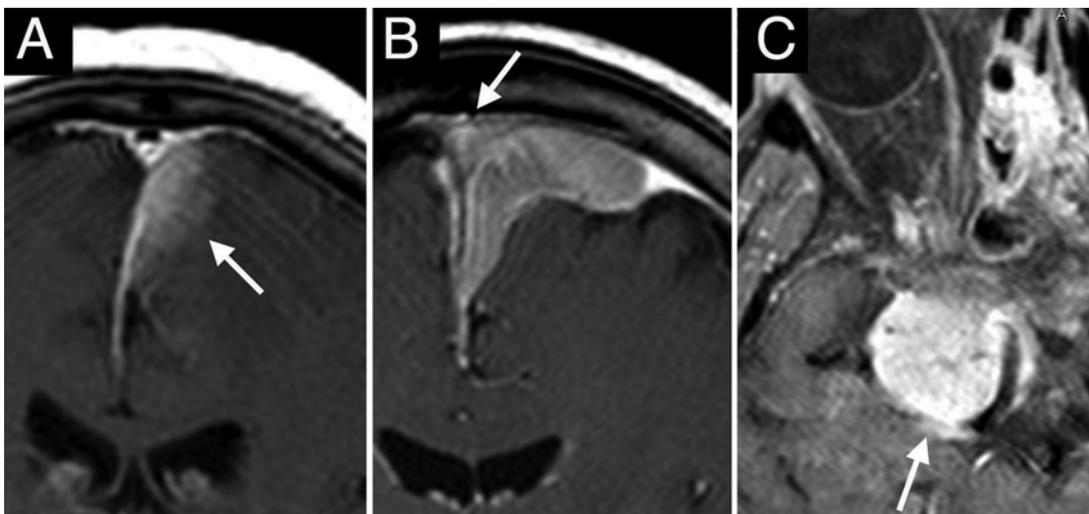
Magnetic resonance images showing examples of unclear tumor borders. Unclear borders (arrows) between the tumor and the brain parenchyma (A), the large venous sinus (B), and the abutting blood vessel (C) may cause some technical problems in volumetry.
